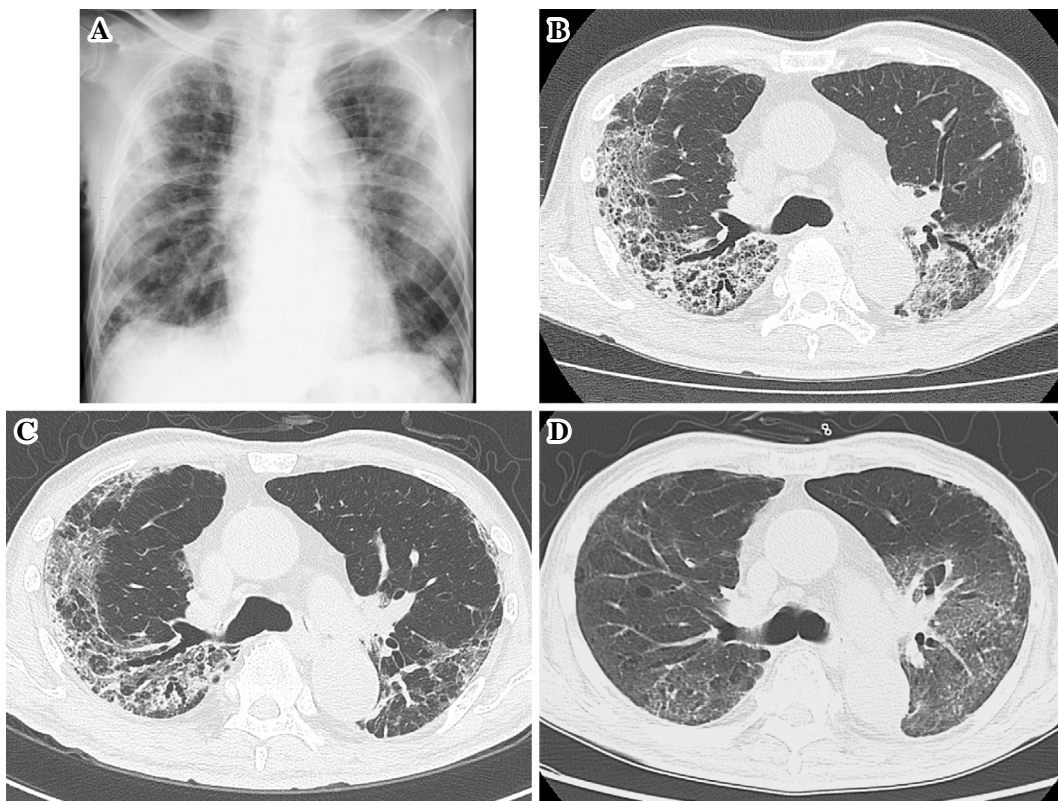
The radiological findings on admission are shown. (A) Chest radiography shows bilateral peripheral reticular shadows. Chest computed tomography demonstrates bilateral diffuse ground-glass opacity and the progression of traction bronchiectasis (B) on the day of admission, (C) partial improvement on the 8th day of treatment, and (D) recurrence of interstitial pneumonia on the 42nd day.
